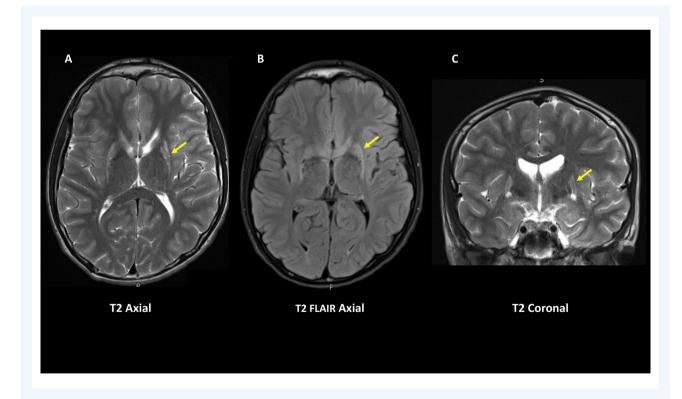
MRI brain (T2 axial, T2 FLAIR axial, T2 coronal) at age 14 years demonstrating bilateral neostriatal hyperintensities and atrophy.
